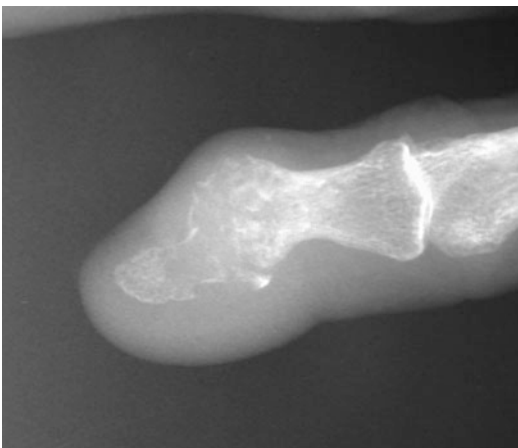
X-ray changes in severe gout-marked destructive changes at the distal intertarsal joint of the big toe (Reproduced, with kind permission, from Prof. Nicholas Manolios)
